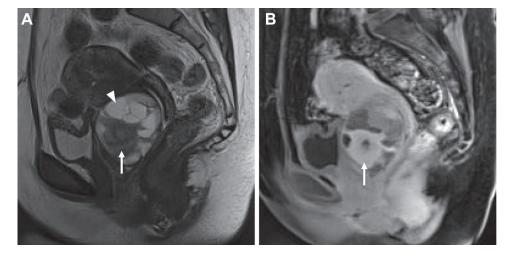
(A) Sagittal T2-weighted image in the same patient again shows the large mass with cystic (arrowhead) and solid (arrow) components arising from the anterior cervical wall. (B) Postcontrast fat-saturated T1-weighted sagittal image demonstrates avid enhancement within the solid component (arrow).
